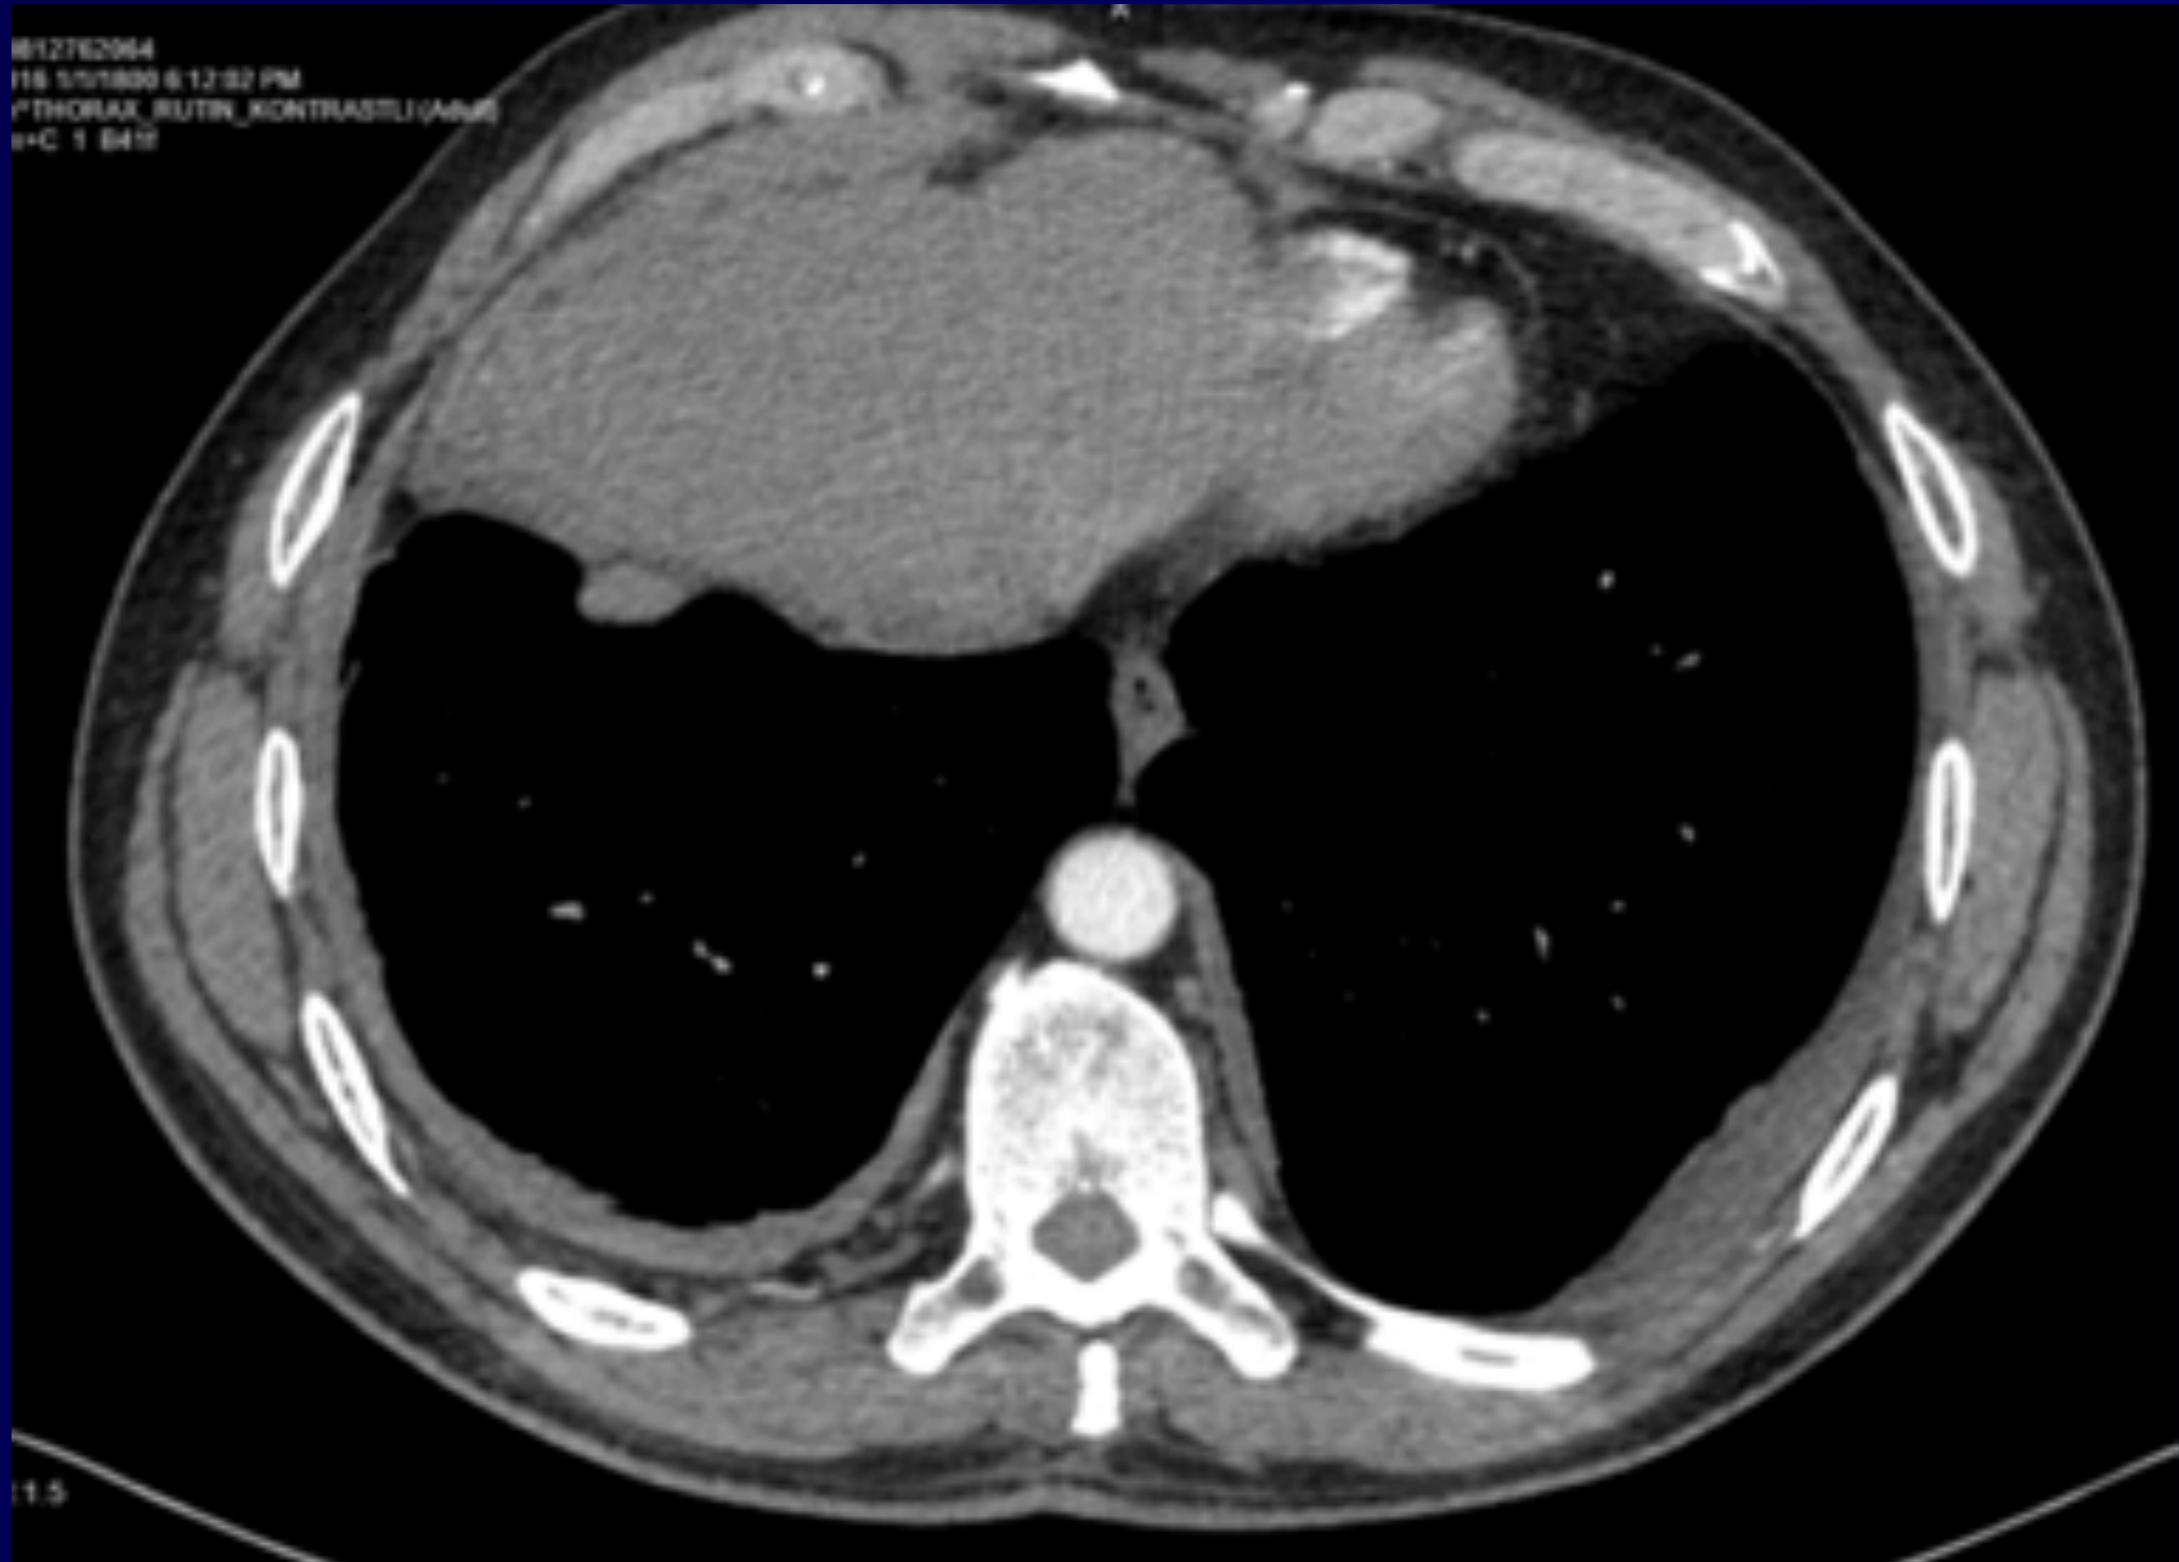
Tuberculous pleuritis (SUVmax: 5.6).
